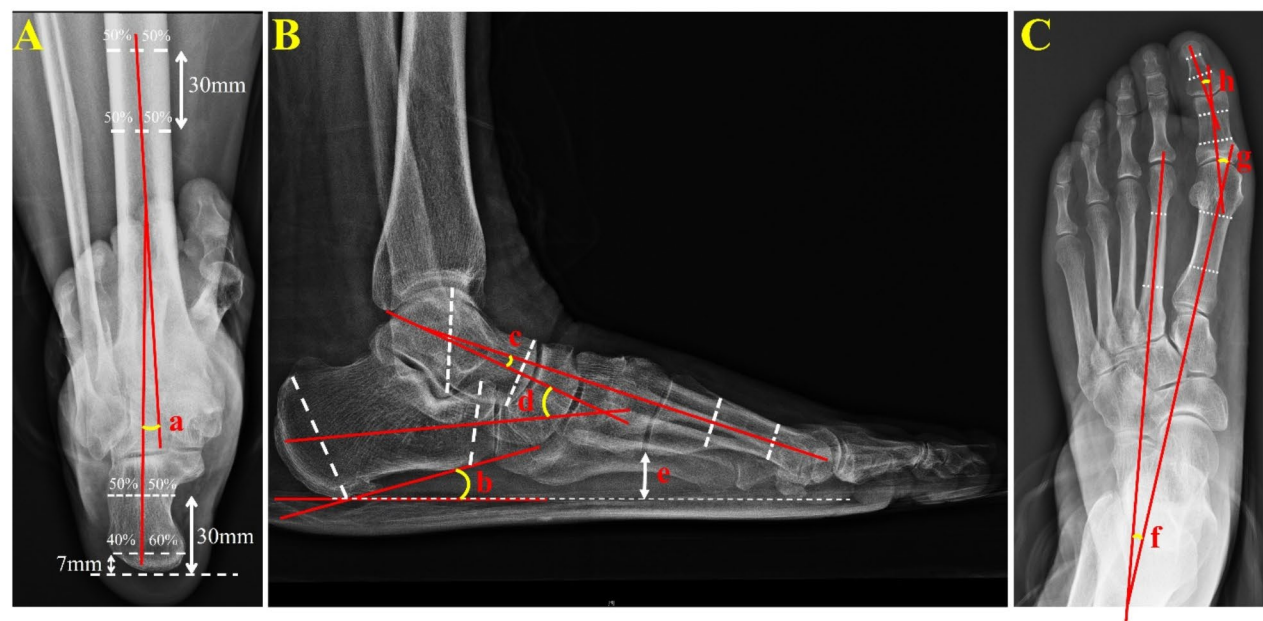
(A) Hindfoot alignment angle (HA) (a) was measured on preoperative long axial weight-bearing view of the hindfoot, which was defined as the angle (a) between tibial anatomical axis and calcaneal longitudinal axis. The tibial anatomical axis was determined by the extending line through two diaphyseal midpoints (30 mm apart) that bisect the tibial. The calcaneal longitudinal axis was determined by the extending line through two points: one point is the 40% mark of a horizontal line 7 mm above the most distal end of the calcaneus, and the other is the midpoint of a horizontal line 30 mm above the most distal end of the calcaneus. Notably, hindfoot valgus was defined as the positive value. (B) Morphological parameters of medial longitudinal arch were measured on preoperative lateral weight-bearing radiograph of foot: (b) calcaneal pitch angle (CPA), (c) lateral talus-first metatarsal angle (Meary's angle), (d) lateral talocalcaneal angle (LTCA), (e) height of the medial cuneiform (HMC). (C) Morphological parameters of hallux valgus deformity were measured on preoperative AP weight-bearing radiograph of foot: (f) intermetatarsal angle (IMA), (g) hallux valgus angle (HVA), (h) hallux interphalangeal angle (HIA)
